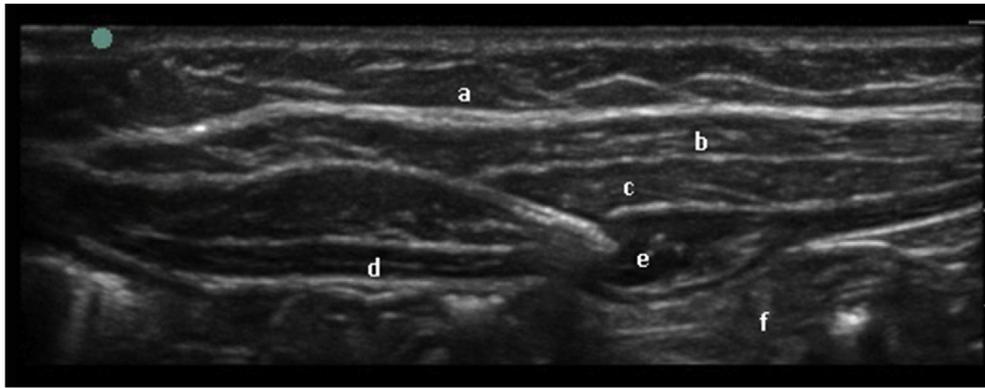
Ultrasound-guided transverse abdominal plane block (depth 1.8 cm). (a) Subcutaneous tissue; (b) external oblique muscle; (c) internal oblique muscle; (d) transversus abdominis muscle; (e) transversus abdominis plane (needle tip and LA injection visible on image); (f) peritoneal cavity.
